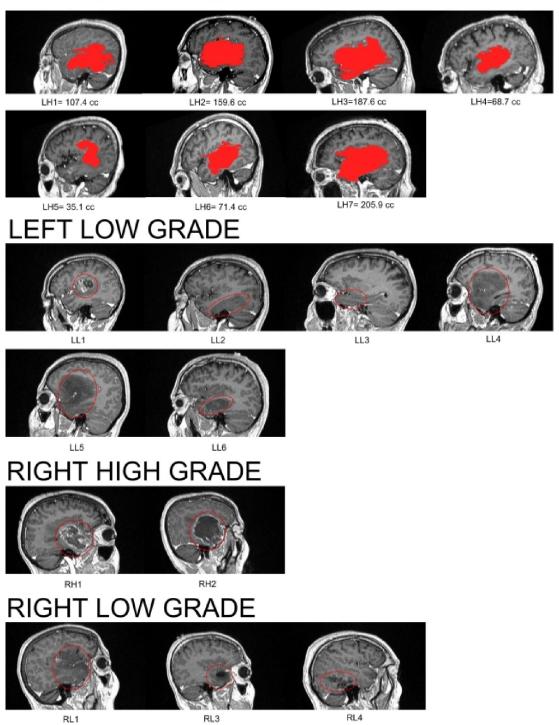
Sagittal sections of the MRI scans of each of the tumour patients. Scans from patients RH3 and RL2 were not available. Lesion reconstruction and lesion volume were obtained from the only left high grade patients.
